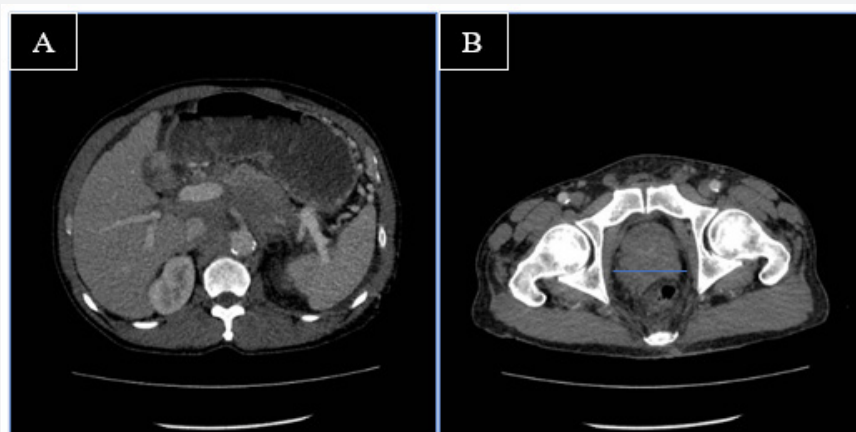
MRI of the abdomen revealed significant enlargement of the prostate.
